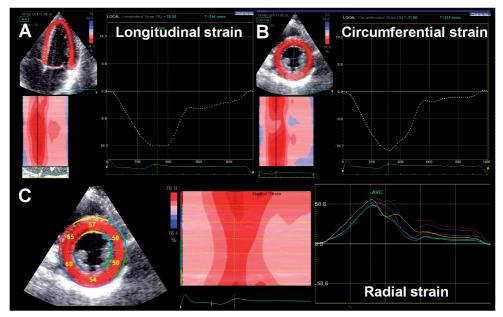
Two-dimensional speckle tracking echocardiography enables comprehensive assessment of active deformation of the myocardium in all 3 planes of cardiac motion, that is angle-independent on ultrasound insonation. Longitudinal strain (panel A) is calculated from apical views of the left ventricle (LV). Circumferential (panel B) and radial strain (panel C) are calculated from mid-ventricular short-axis views of the LV.
